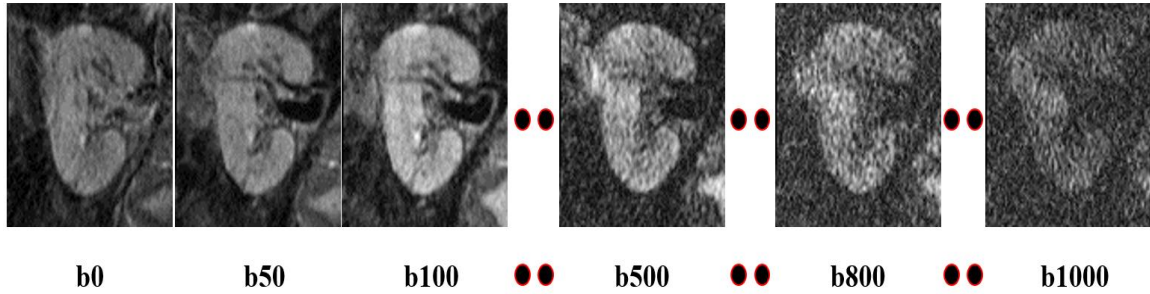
Example of an DW-MRI sequence at different b-values.
